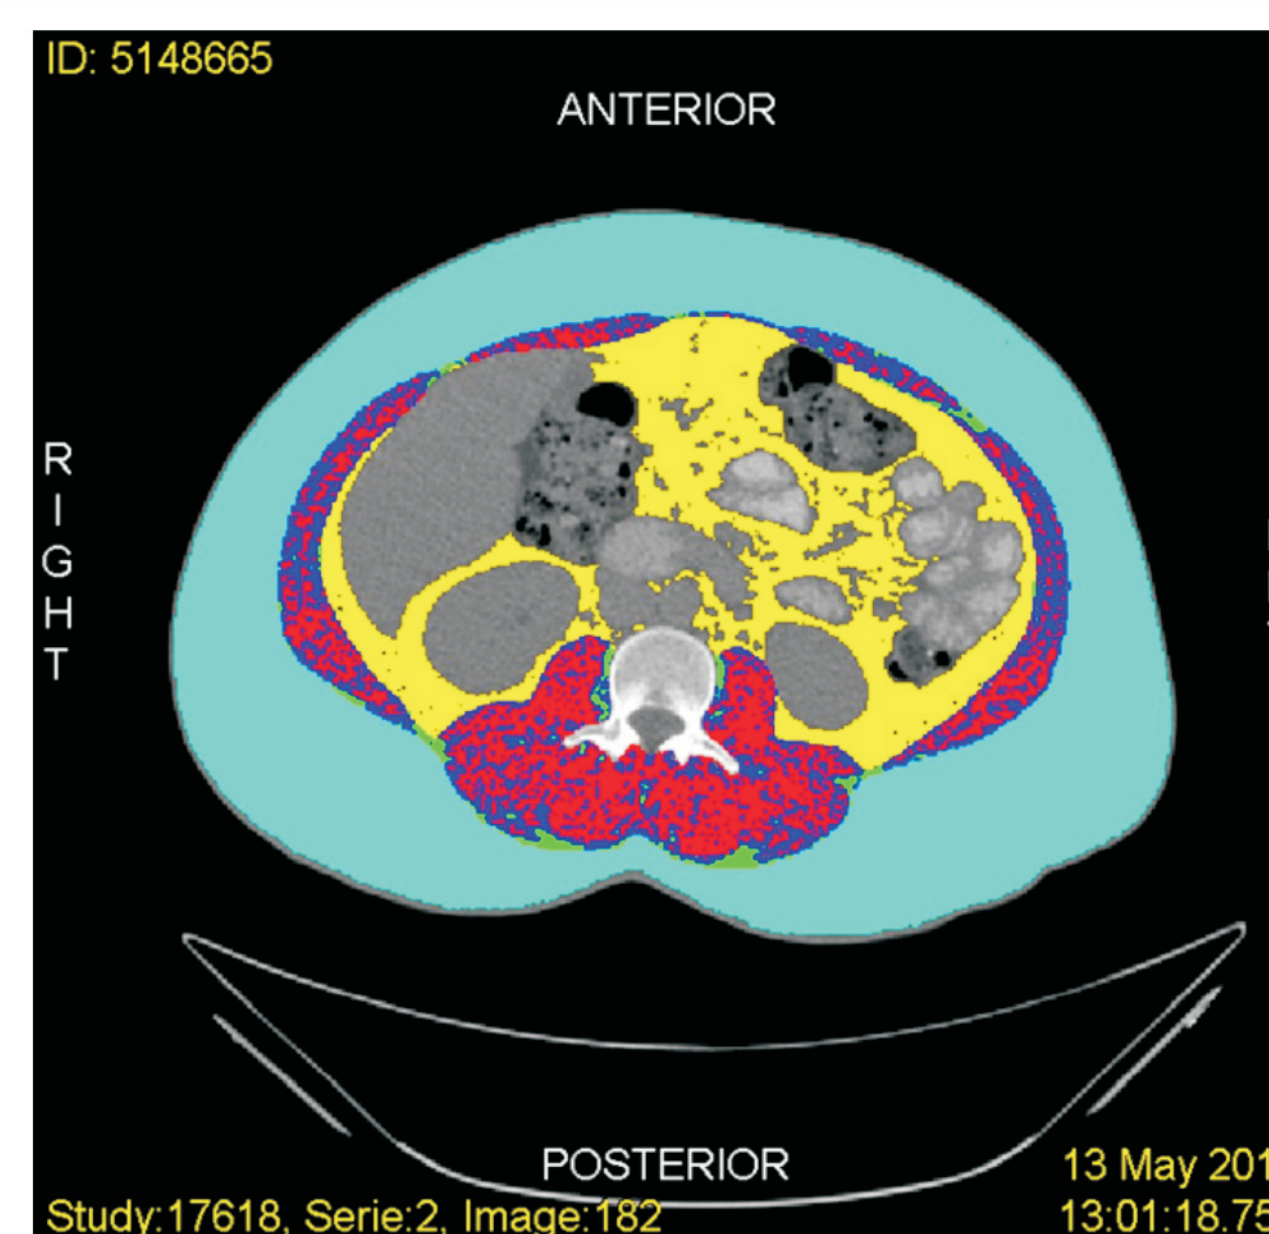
CT with SliceOmatic 5.0 assessment. Female, 33yrs, cervical cancer diagnosis, stage IIB, 88kg and BMI = 34.0
